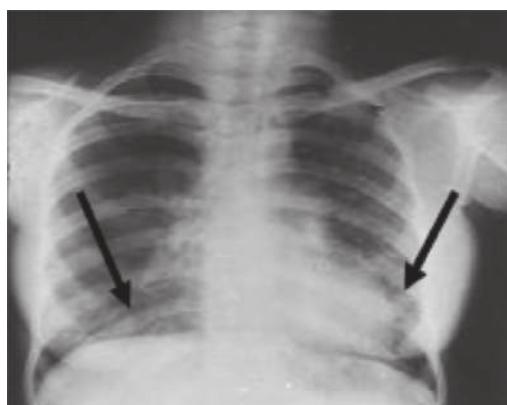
Radiographic changes of early ILD in a patient with SSc
